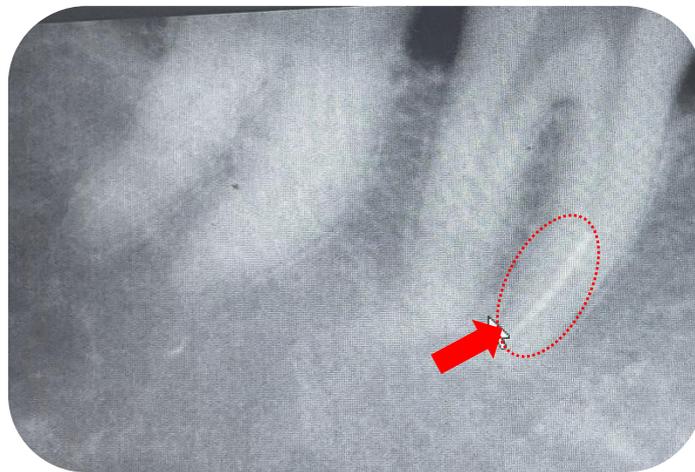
' : Periapical radiograph revealing a fractured instrument located in the apical third of the right mandibular second molar
